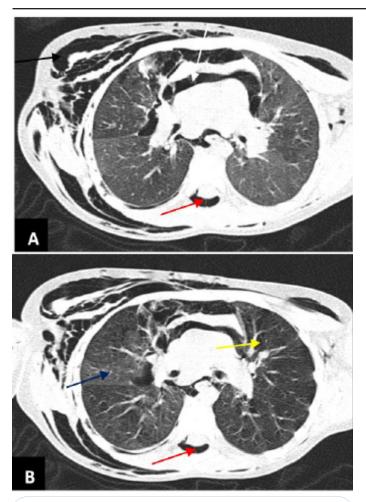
(A). Non enhanced pulmonary CT (transverse section) showing extensive subcutaneous emphysema (black arrow), pneumomediastinum and pneumorrhachis (white and red arrow). (B). Areas of "ground glass opacities" (blue arrow) and interstitial emphysema (yellow arrow).
